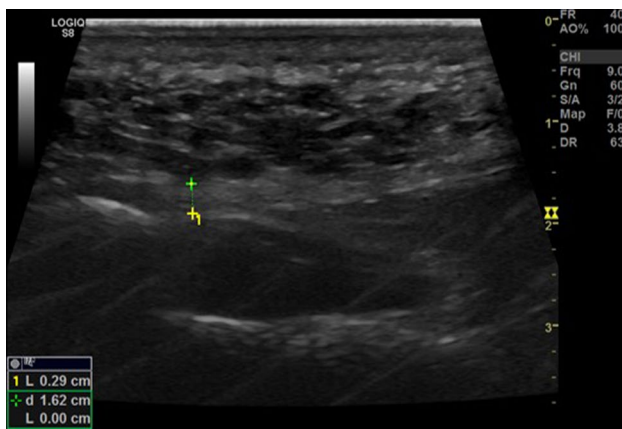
Plantar fascia thickness measured by ultrasonogram in an asymptomatic foot
